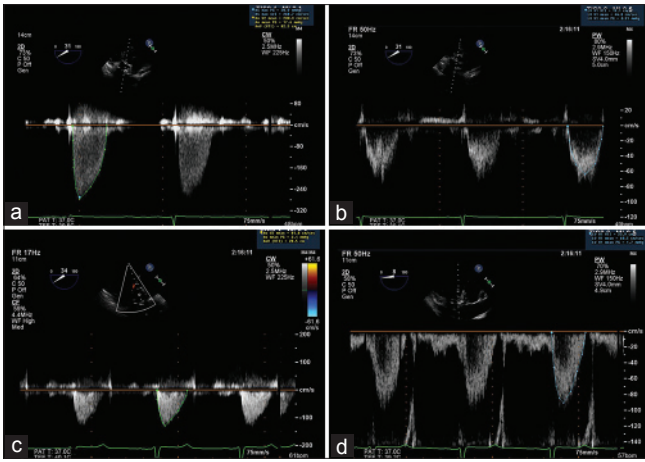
Pre- and post-transcatheter aortic valve replacement (TAVR) transesophageal echocardiogram in a patient with paradoxical low-flow, low-gradient aortic stenosis with preserved left ventricular ejection fraction. (a) Pre-TAVR aortic valve (AV) maximum peak gradient (PG) = 29 mmHg, AV mean PG = 18 mmHg. (b) Pre-TAVR left ventricular outflow tract (LVOT) velocity time integral (VTI), Stroke Volume index (SVi) = 29 mL/m². (c) Post-TAVR AV maximum PG = 3 mmHg. (d) Post-TAVR LVOT VTI, SVi = 36 mL/m².
